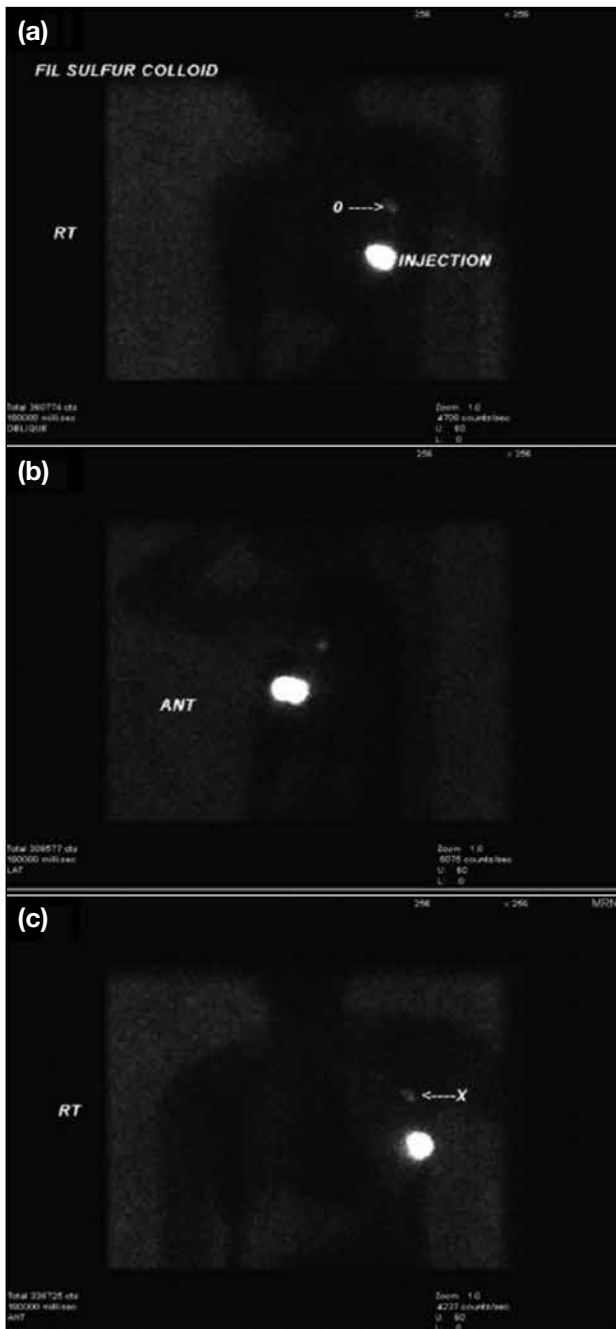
Scintigraphic images of (a) left anterior-oblique, (b) left lateral, and (c) anterior views of a 52-year-old woman who underwent sentinel node and occult lesion localisation for high-grade ductal carcinoma in situ. Filtered ^{99m}Tc -labelled sulphur colloid tracer was injected into the tumour at 1-to-2 o'clock position 6 cm from the nipple under sonographic guidance (not shown). A sentinel lymph node was seen cranial to the injected activity in the left axilla, which is marked as 'O' in (a) and 'X' in (c), respectively.
